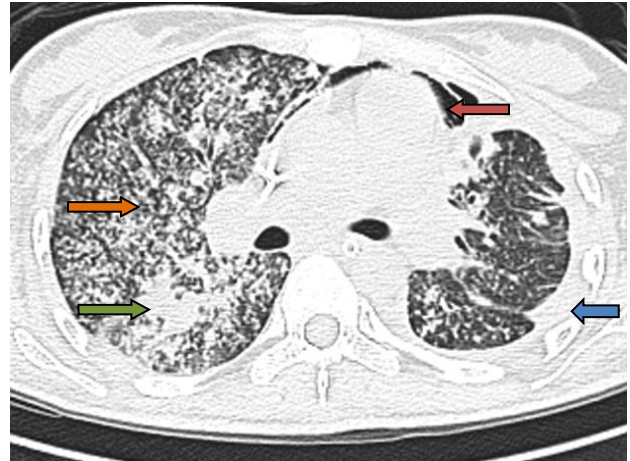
HRCT thorax of the patient showing pneumomediastinum (red arrow), miliary nodules (orange arrow), focal areas of consolidation (green arrow) and left pleural thickening (blue arrow).
